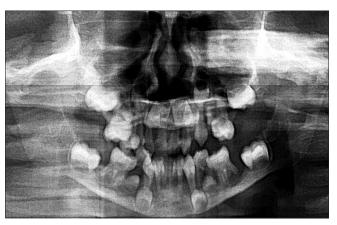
Orthopantomogram showing generalized horizontal bone loss extending up to the apical third of roots
